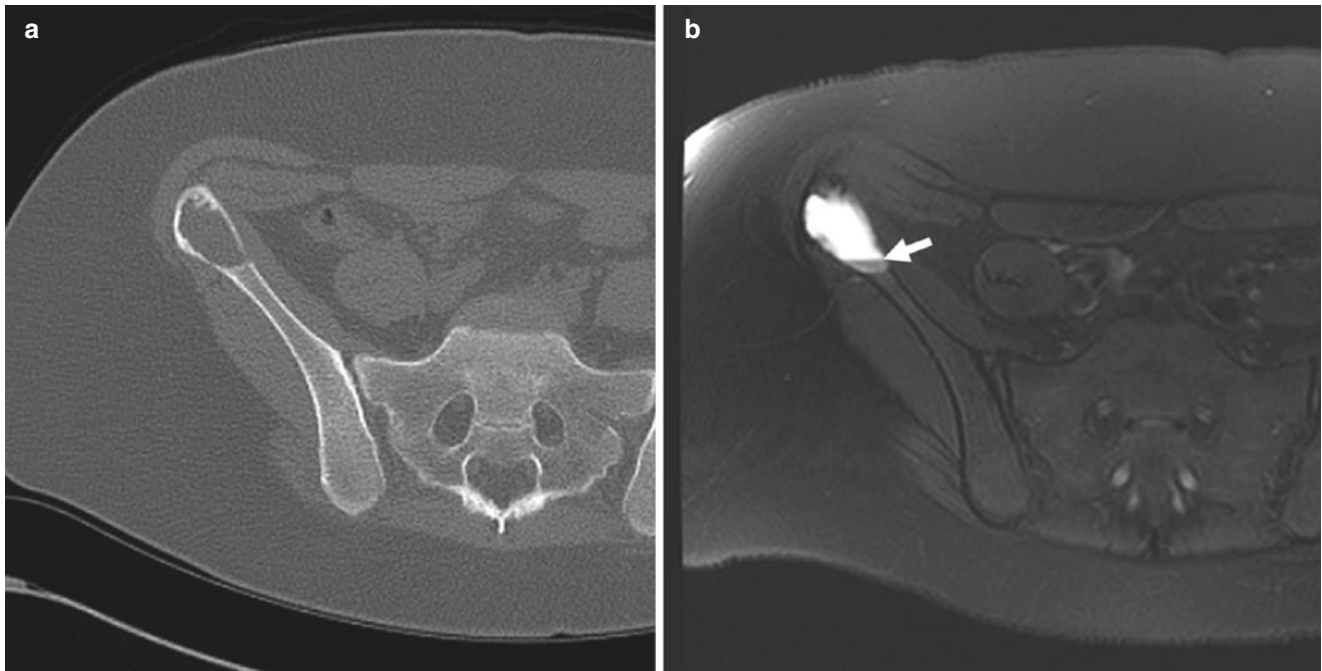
Axial CT of the pelvis (a) demonstrates purely lytic lesion in the right iliac wing. The lesion has a narrow zone of transition, no cortical destruction, no periosteal reaction, and no soft tissue mass. Subsequent axial T2-weighted fat-saturated images of the pelvis show
